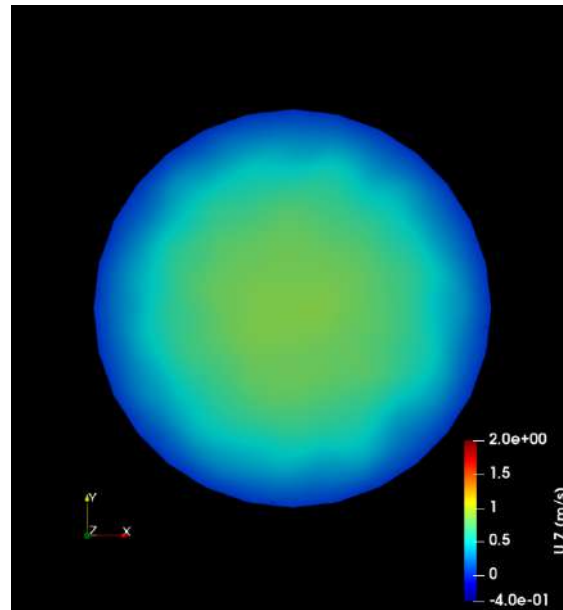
Comparison of LES and 2D PC-MRI velocity distribution in the inlet slice of the stenosis model at Re 2000.
